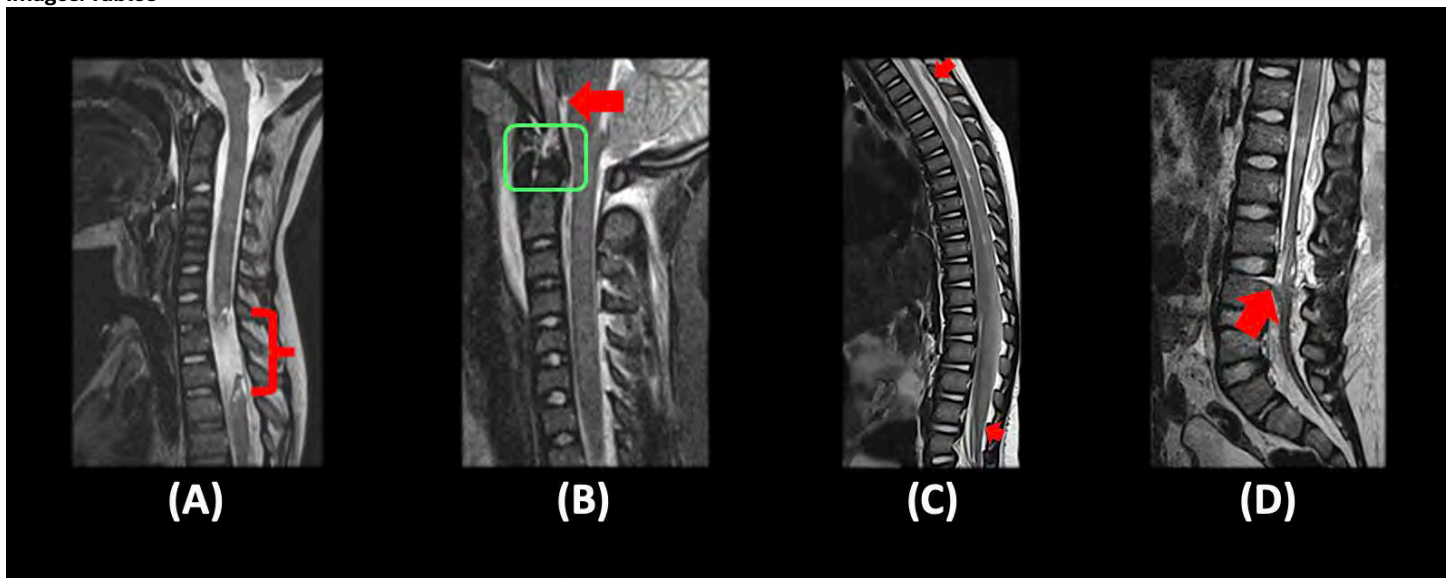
Overview of Non-osseous Pediatric Spinal Injuries on MRI.
